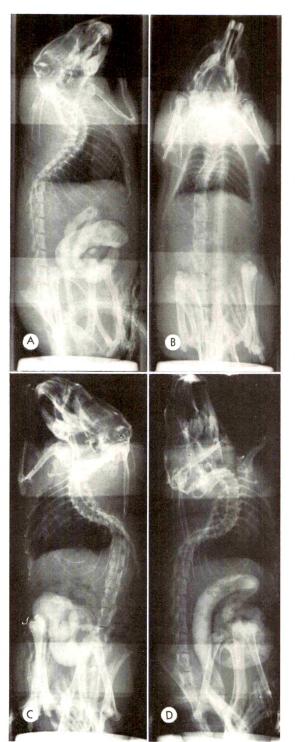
(A and B) One minute forced retention of barium enema containing 4 per cent tannic acid. (A) Roentgenogram obtained 3 minutes after release. (B) Roentgenogram obtained 20 minutes after release. Note complete emptying. (C and D)
